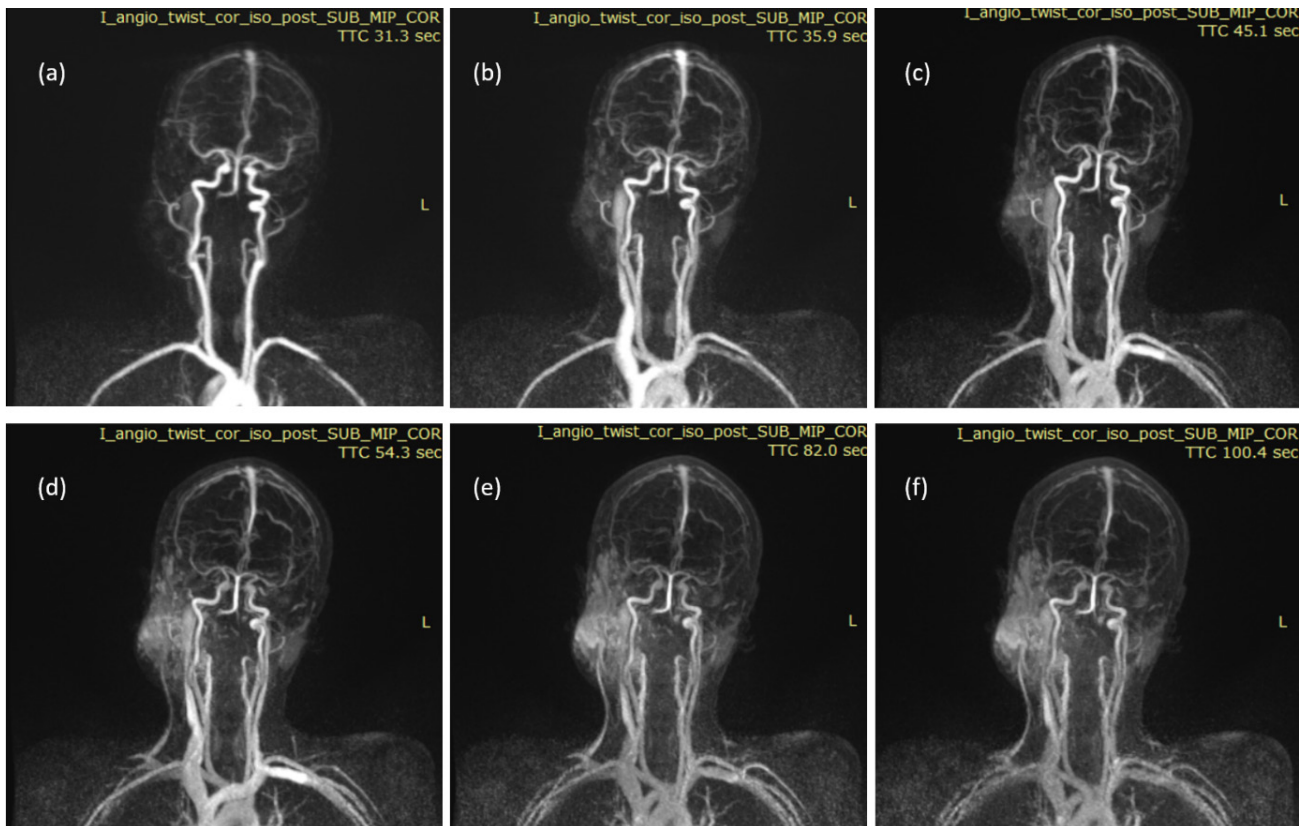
(a-f). Dynamic contrast MRI – TWIST sequence at various time points, showing progressive enhancement of the lesion in the late venous phase. No arterial and early venous phase enhancement. No dilated arterial feeders or draining veins.
